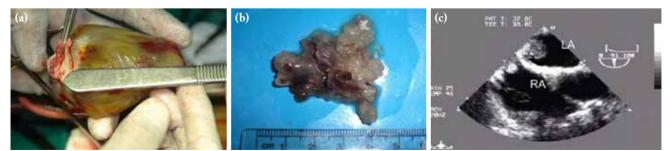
An excised myxoma and postoperative echocardiography showing (a) an excised left atrial myxoma; and (b) an excised multi-headed myxoma. (c) Postoperative transesophageal echocardiography showing a recurrent biatrial myxoma.
